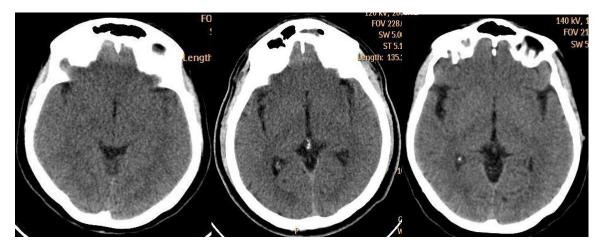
The left-hand side brain CT with 22 mGy CTDIvol, the middle image 25 mGy CTDIvol, and the right-hand side image 30 mGy CTDIvol.
